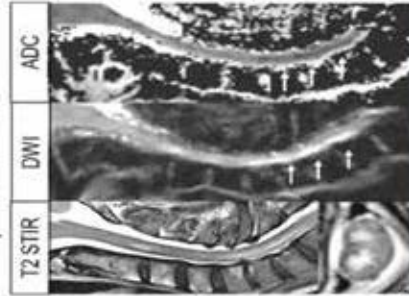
MRI imaging of spinal cord infarction.
